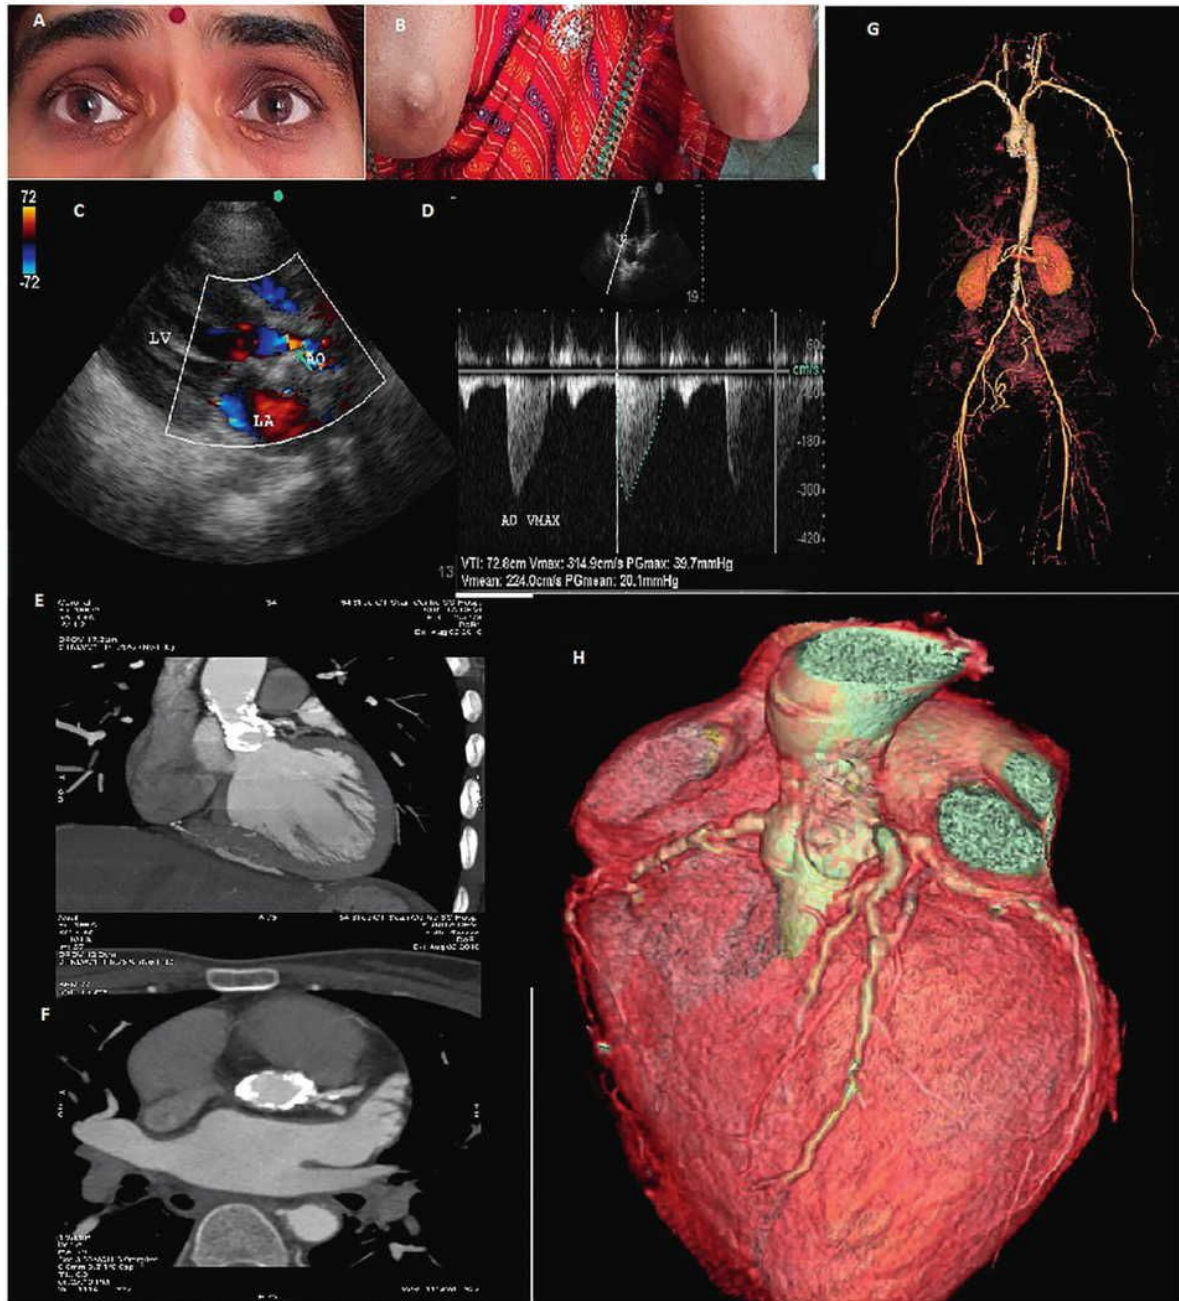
A: Xanthelasma, B: Tuberous xanthomas over extensor aspects of elbow, C: Parasternal long axis view on colour doppler echocardiogram showing turbulence at the supravalvular level in the aorta, D: CW doppler shows a mean gradient of 20 mmHg, E,F: Severe calcification involving the aortic root and ascending aorta on CT, G: Contrast enhanced CT showing significant luminal narrowing in left common carotid, abdominal aorta, H: CT coronary angiography showing diffuse calcified triple vessel disease.
